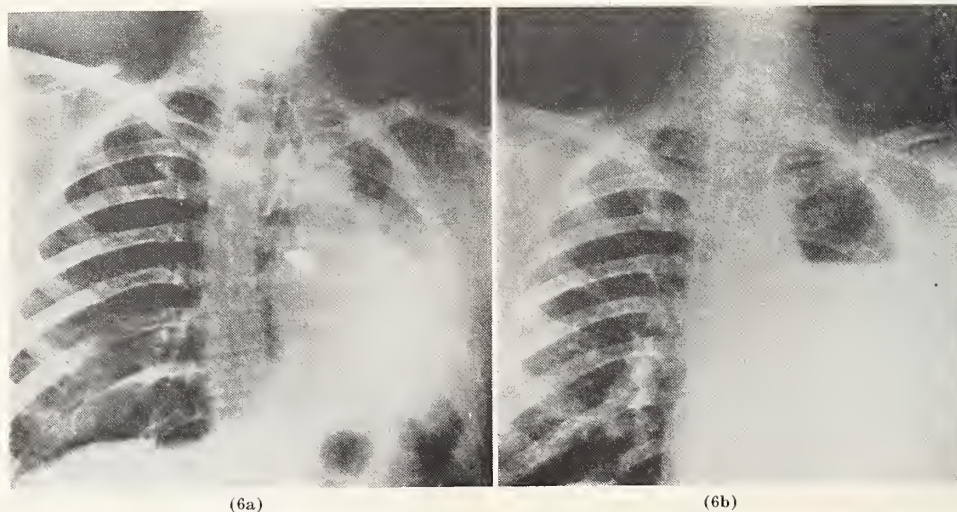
(Case No. 7) (a). X-ray of the chest following injection of iodized oil. Note obstruction of the left primary bronchus by carcinoma with atelectasis of the left lung. (b). X-ray appearance two weeks following resection of the left lung.
